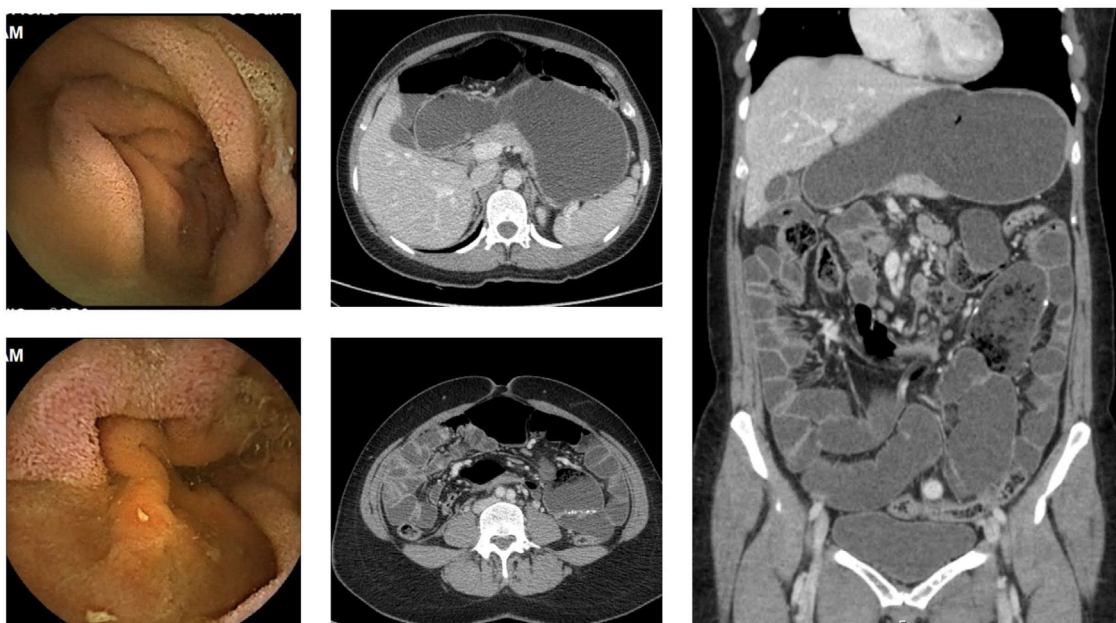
Capsule endoscopy and CT enterography images, 6 months after the acute event. Signs of pneumatosis are absent with few enteric stasis near the enteric anastomosis in CT enterography.
